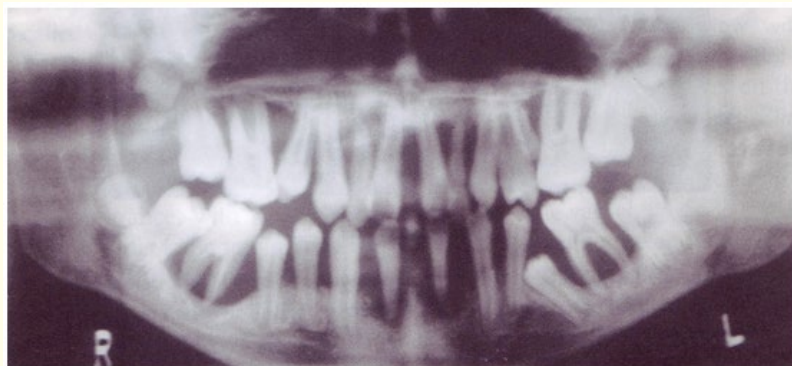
A pan-oral radiograph of a case of Aggressive Periodontitis in an 18 year-old male teen-ager, at Stage-IV, and Grade-C, Note the extensive loss of alveolar bone especially around the molars and incisors. OB does is rarely visible in radiographs.
